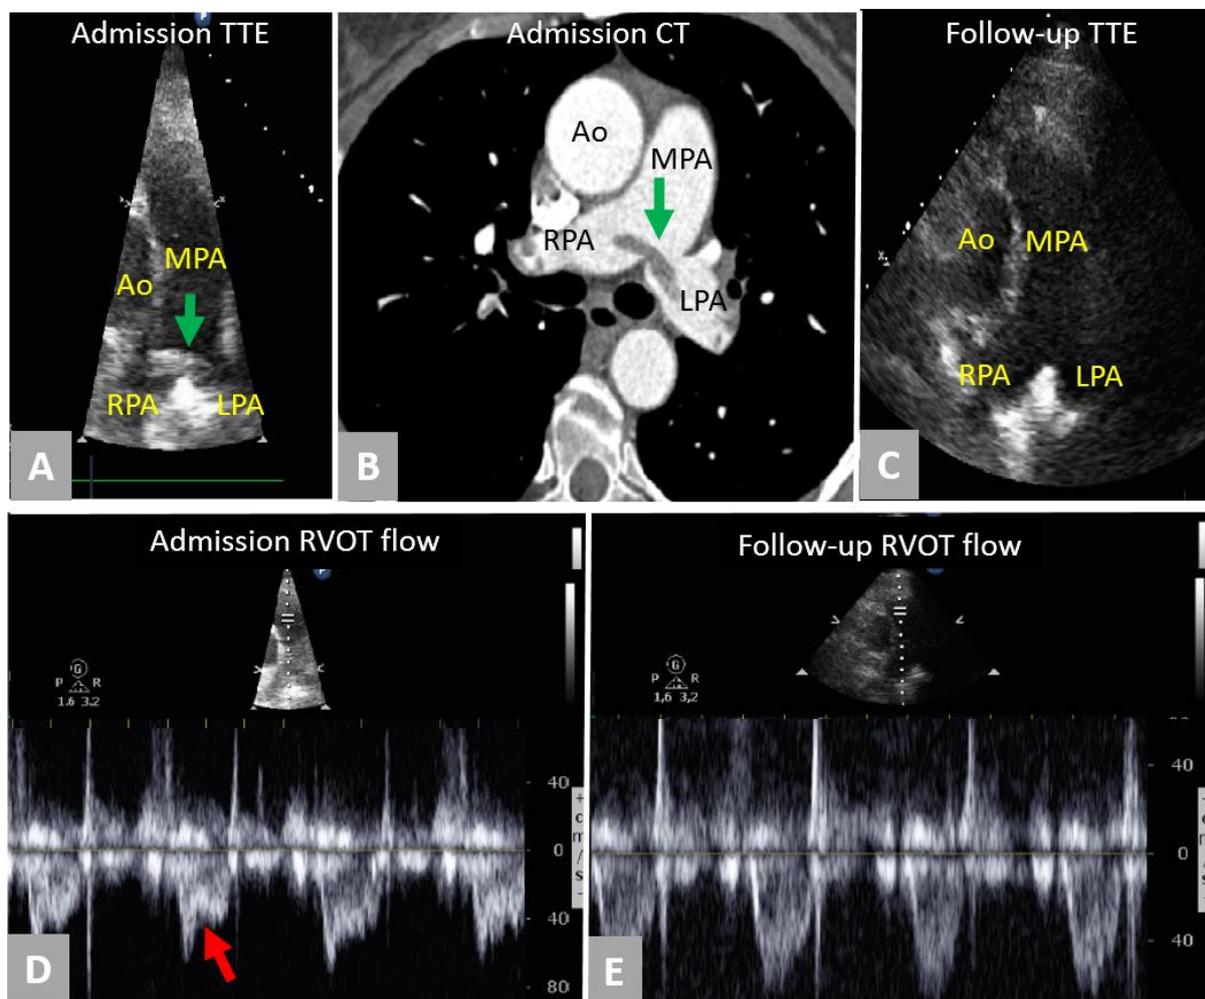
A: Transthoracic echocardiography showing a thrombus at the bifurcation of main pulmonary artery (green arrow). B: Computed tomography confirming the saddle pulmonary embolism and the thrombotic material in left and right pulmonary arteries. C: Follow-up
